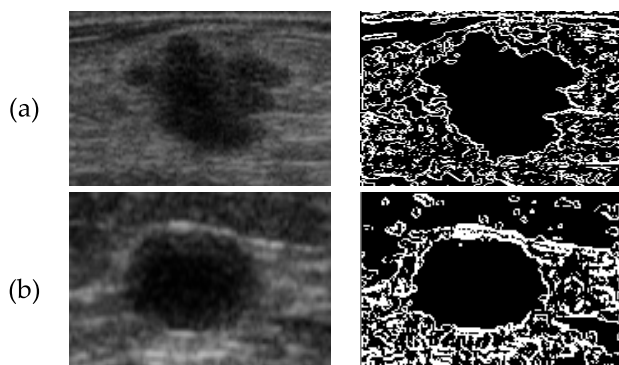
Mass of ultrasonic breast image and its edge. (a) Malignant image; (b) Benign image.
